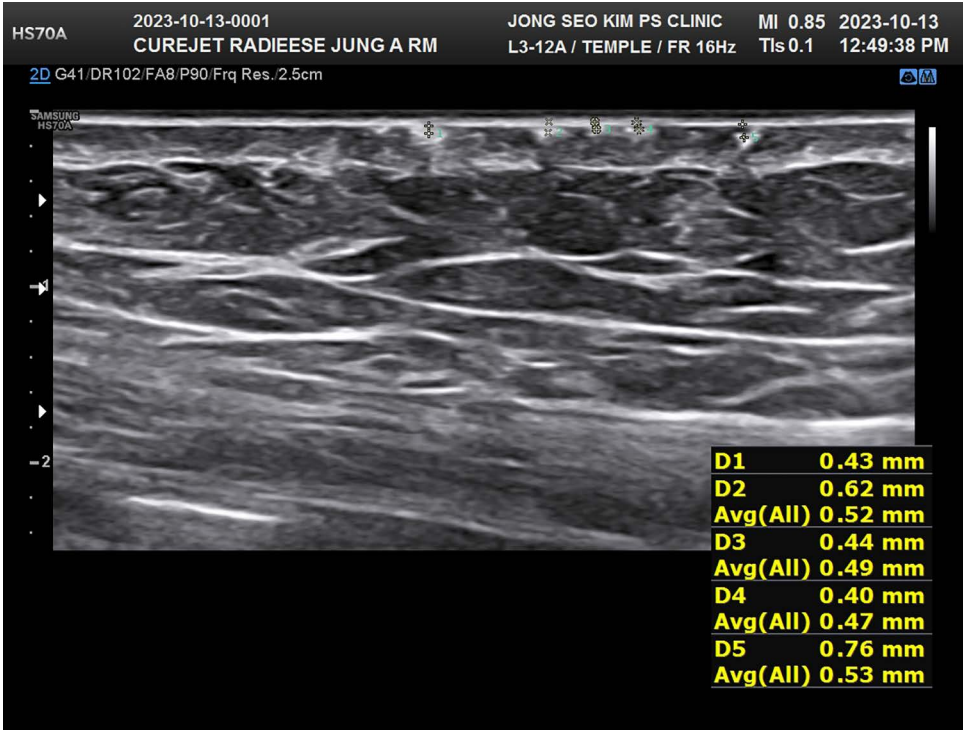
Ultrasound image of skin cross-section following a CaHA injection with a needle-free injector. The image demonstrates key skin layers postinjection. Top layer, The epidermis, appearing as a thin, superficial layer. Middle layer, The hypoechoic dermis, showing scattered white dots representing CaHA particles. These particles are dispersed laterally within the dermis, creating a subcision-like effect, potentially aiding in scar and stretch mark treatment. Right-hand box, Measured injection depths at 5 points (D1–D5) ranged from 0.40 to 0.76 mm, with an overall average of 0.53 mm. These measurements indicate the injector’s ability to deliver material consistently, with slight variations potentially attributed to differences in skin thickness or injector positioning. The injected CaHA particles stimulate collagen production, improving skin texture and appearance over time.
